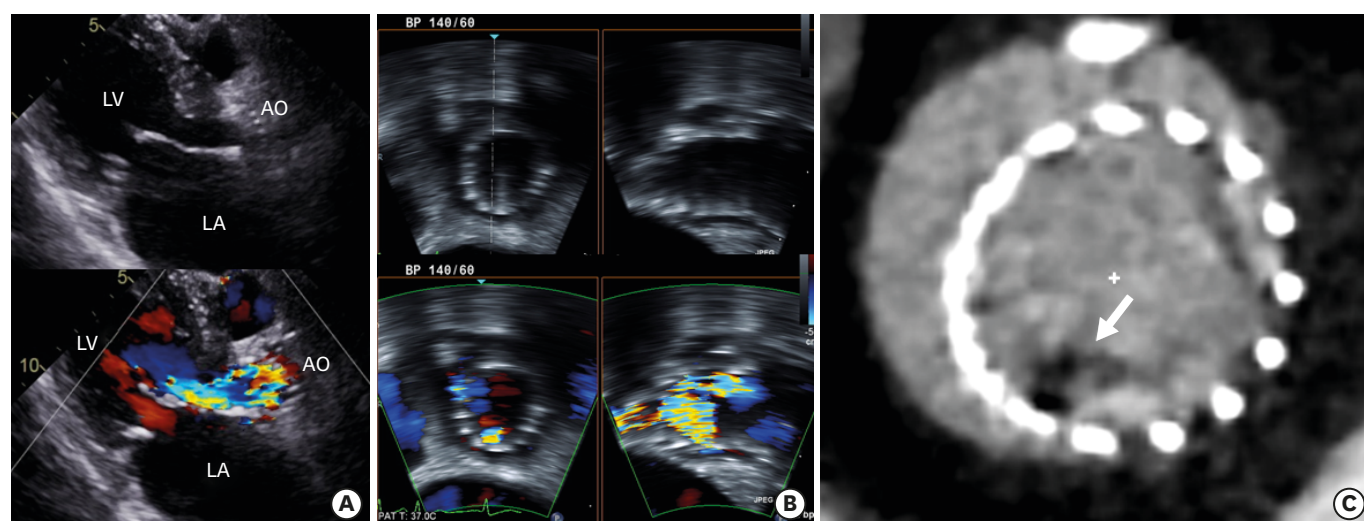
Pre-operative images. (A) Transthoracic echocardiography showed eccentric severe aortic regurgitation with a highly turbulent jet. (B) Transesophageal echocardiography showed eccentric severe aortic regurgitation without vegetation and abnormal leaflet thickening. (C) Computed tomography showing contrast filling defect (white arrow) within a CoreValve-prosthesis in axial view.
